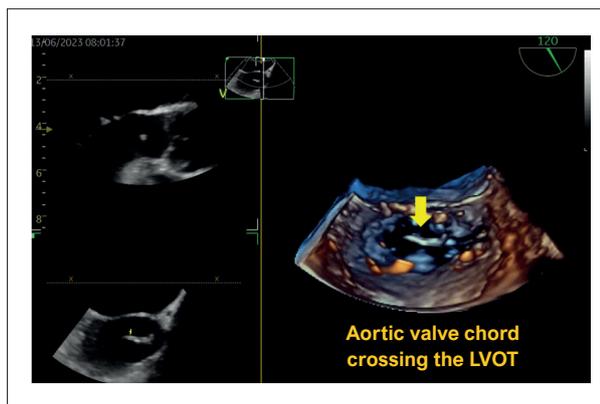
3D Transesophageal Echocardiogram, in 4D Zoom mode, with visualization from the ventricular view, showing a filamentary lesion crossing the left ventricular outflow tract.
